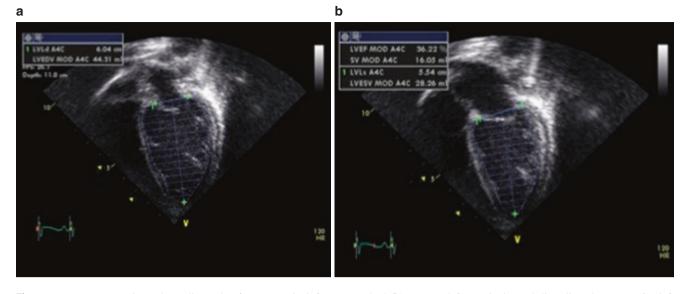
Demonstrates 2D echocardiography from an apical fourchamber view with tracing of the LVEDV (a) and of the LVESV to allow for calculation of the ejection fraction (EF) using the Simpson's
